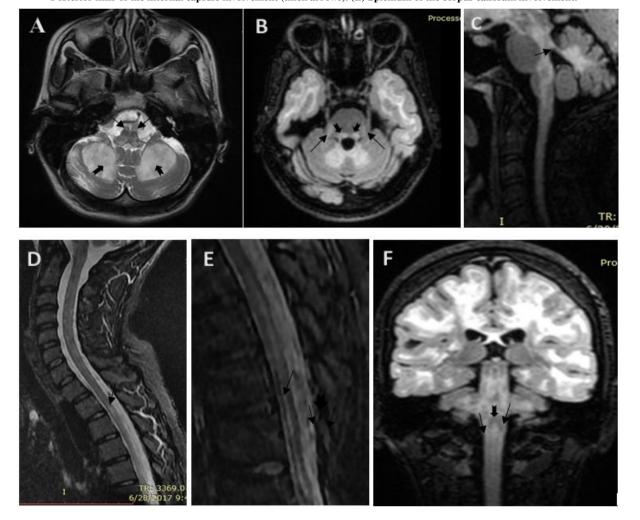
(A) Pyramidal tract of the medulla oblongata (thin arrows) and cerebellar white matter involvement (thick arrows) in axial T2-weighted and Flair. (B) Intra-parenchymal part of the trigeminal nerves(thin arrows) and medial lemniscus involvement (thick arrows). (C) Superior cerebellar peduncle involvement. (D, E) Lateral corticospinal tracts of the spinal cord involvement. (F) Lateral corticospinal tract (thin arrows) and dorsal column involvement(thick arrow).
